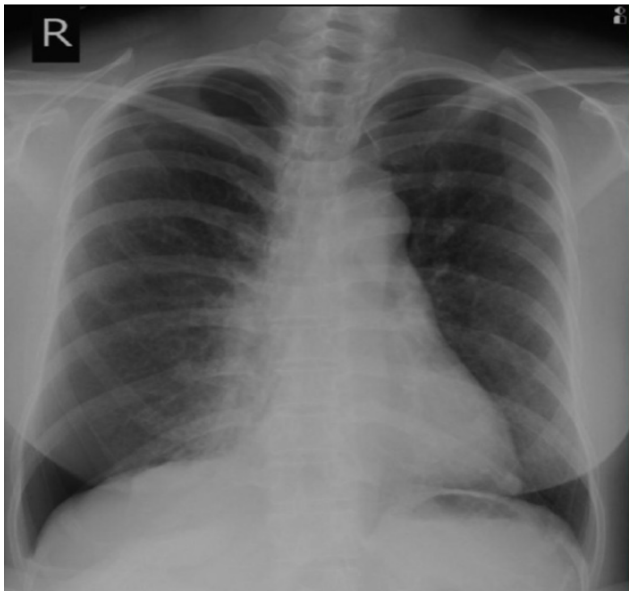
Chest radiograph with pneumothorax in the right with minimal pleural effusion
